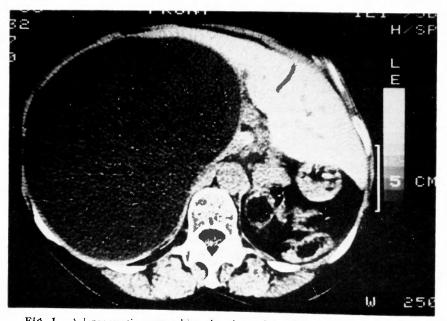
A large cystic mass taking the place of the right hepatic lobe on CT
